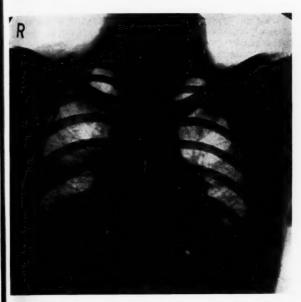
Radiograph showing the mediastinal abscess which developed during convalescence and which was treated by left-sided costo-transversectomy. The right pleural cavity was still being drained at this time.
